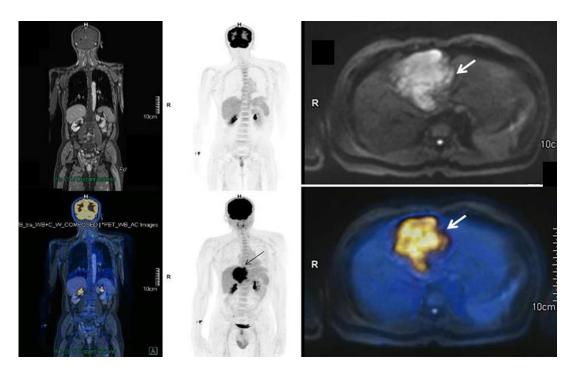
Whole body FDG PET/MRI (3T) in a 44-year-old male with biopsy proven poorly differentiated HCC. (Left) upper row: coronal MR, lower row: fused PET/MR. (Middle) MIP image, (Right) upper row: transaxial MR liver, lower row: fused PET/MR images. PET/MR imaging was performed using multiplanar T1, T2, STIR, DWI, Dixon and post contrast VIBE sequences and fused with PET images. Images reveal [¹⁸F]FDG avid large arterially enhancing lesion (arrow) in segment IVa / IVb of liver measuring 8.8 x 7.5 cm, extending into segment VIII and tiny lesions in segment II (SUVmax 3.4). There is associated [¹⁸F]FDG avid tumour thrombus occluding left portal vein and along the middle hepatic vein and infra diaphragmatic (IVC) Inferior venacava (SUVmax 18.8). No nodal or distant metastases noted.
